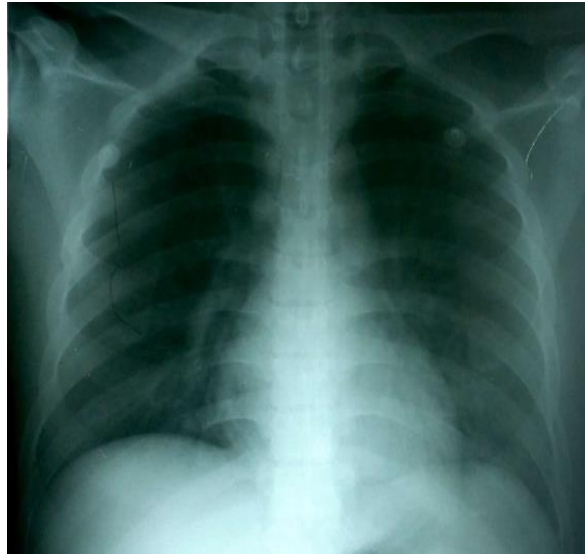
Chest X-Ray on Day 11 of Admission Showing Improvement after Treatment
